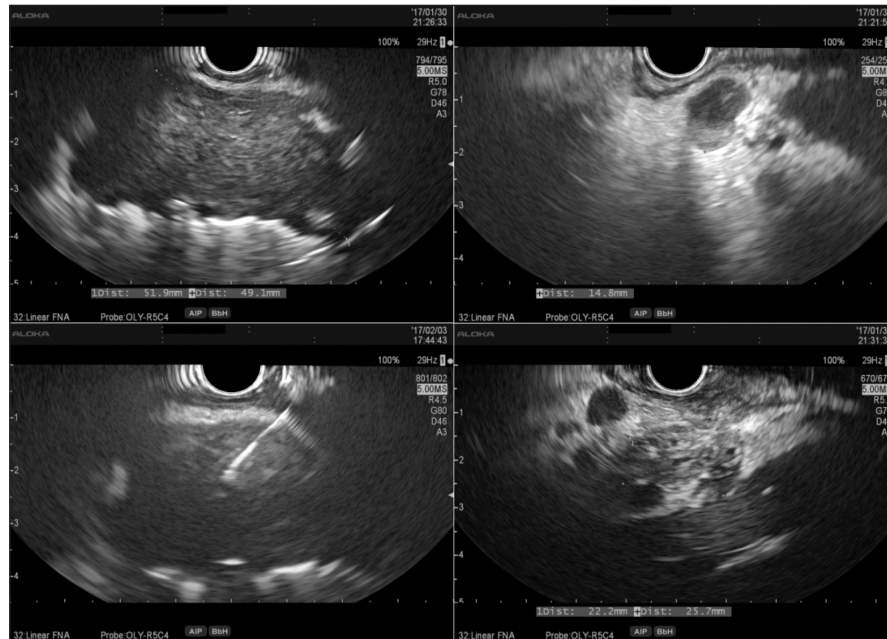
Endoscopic ultrasound and fine needle aspiration (FNA) of the caudal pancreatic mass and the mediastinal adenopathies
